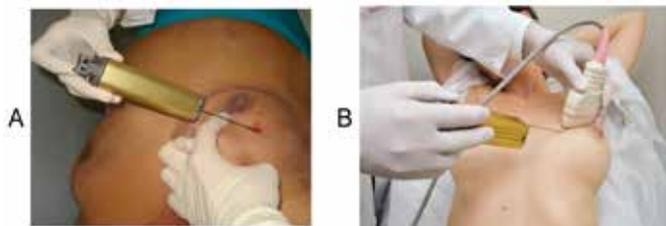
Core needle biopsy. A. Free hand. B. Ultrasound guided. C. Core biopsy ultrasound. Needle positioned before shooting.
